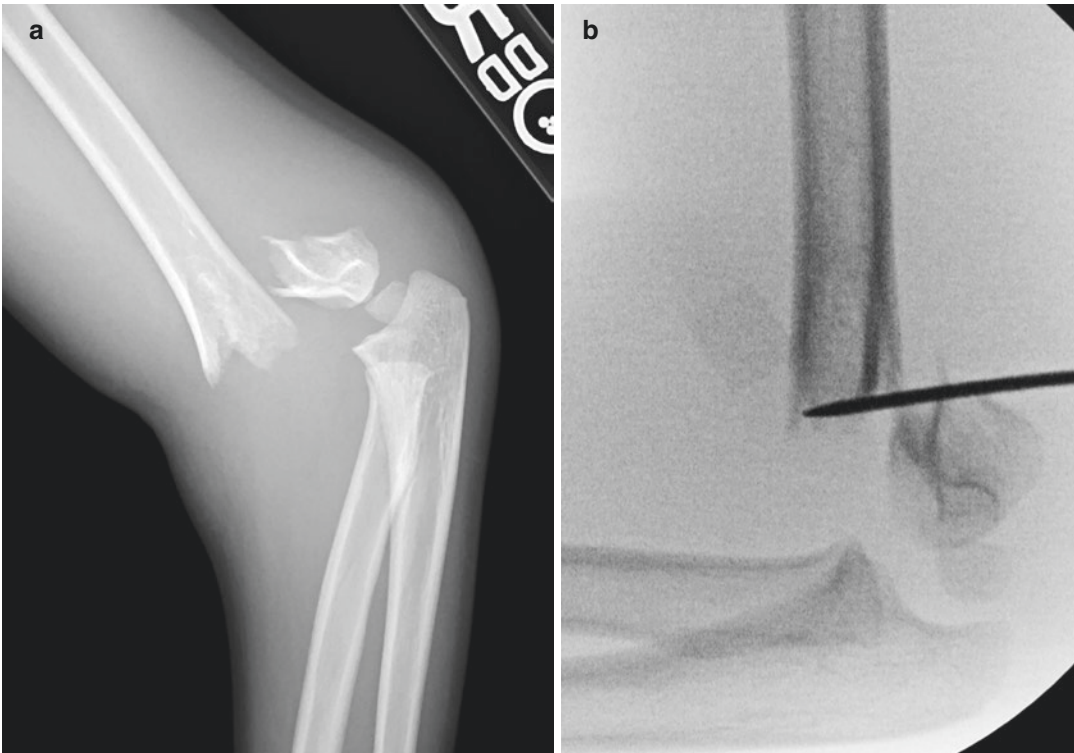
(a–c). (a) Lateral x-ray of a widely displaced Type III supracondylar fracture that proved difficult to reduce. (b) Under C-arm control the blunt end of a
